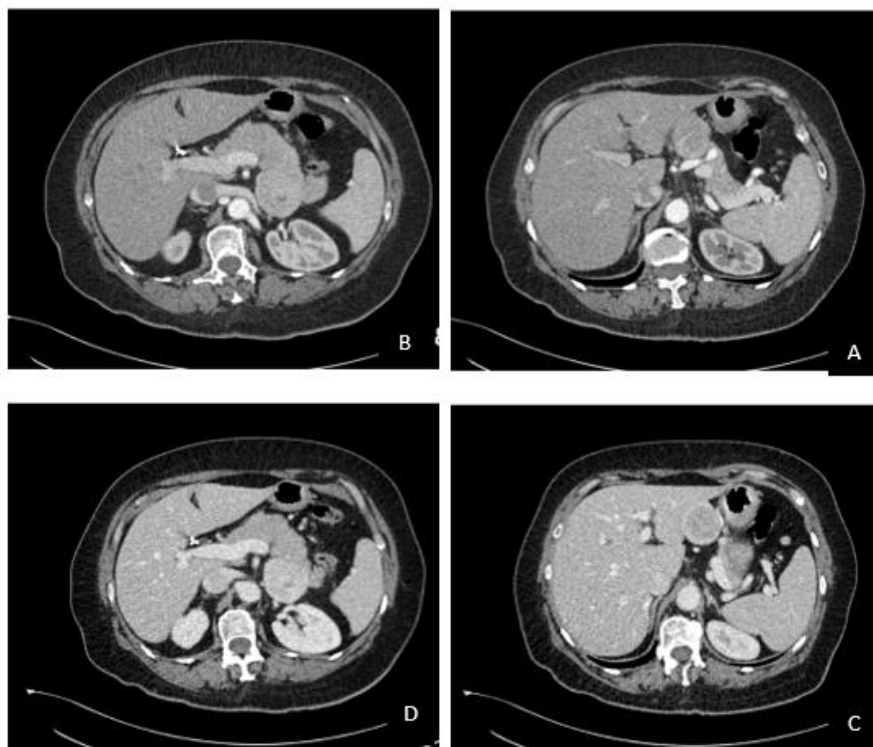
Dynamic contrast-enhanced computed tomography (CT) images of the described case demonstrating two solitary fibrous tumor metastases involving the body and tail of the pancreas. During the arterial phase (A, B), the mass appears well limited and is enhanced at the periphery with a non-enhanced central area. Subsequent venous phase imaging (C, D) shows progression of enhancement of the tumor edges, the masses are clearly demarcated from the pancreatic parenchyma and the central non-enhanced area is compatible with necrosis. The liver parenchyma adjacent to the body mass is compressed by the resulting mass effect.
